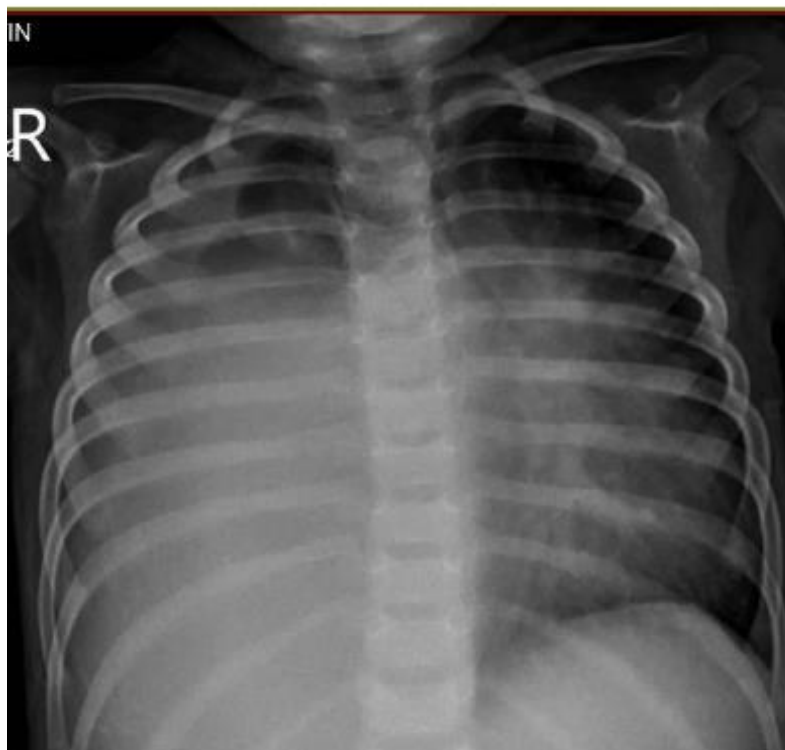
Chest radiography showing a homogeneous opacity in the right hemithorax
